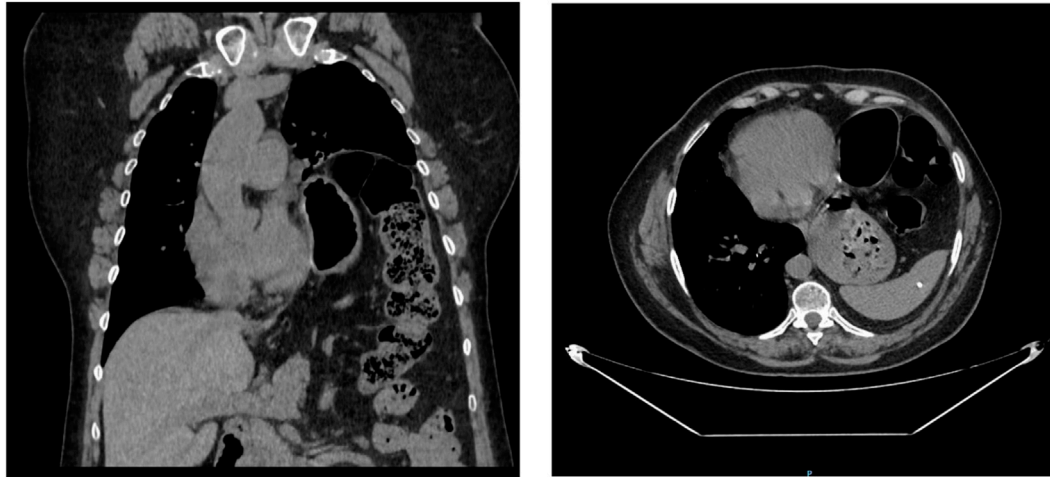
Computed tomography (coronal and transverse section) marked elevation of the left hemidiaphragm and herniation of abdominal contents into the thoracic cavity, including the stomach, spleen, and splenic flexure of the colon with a moderate contralateral mediastinal shift.
